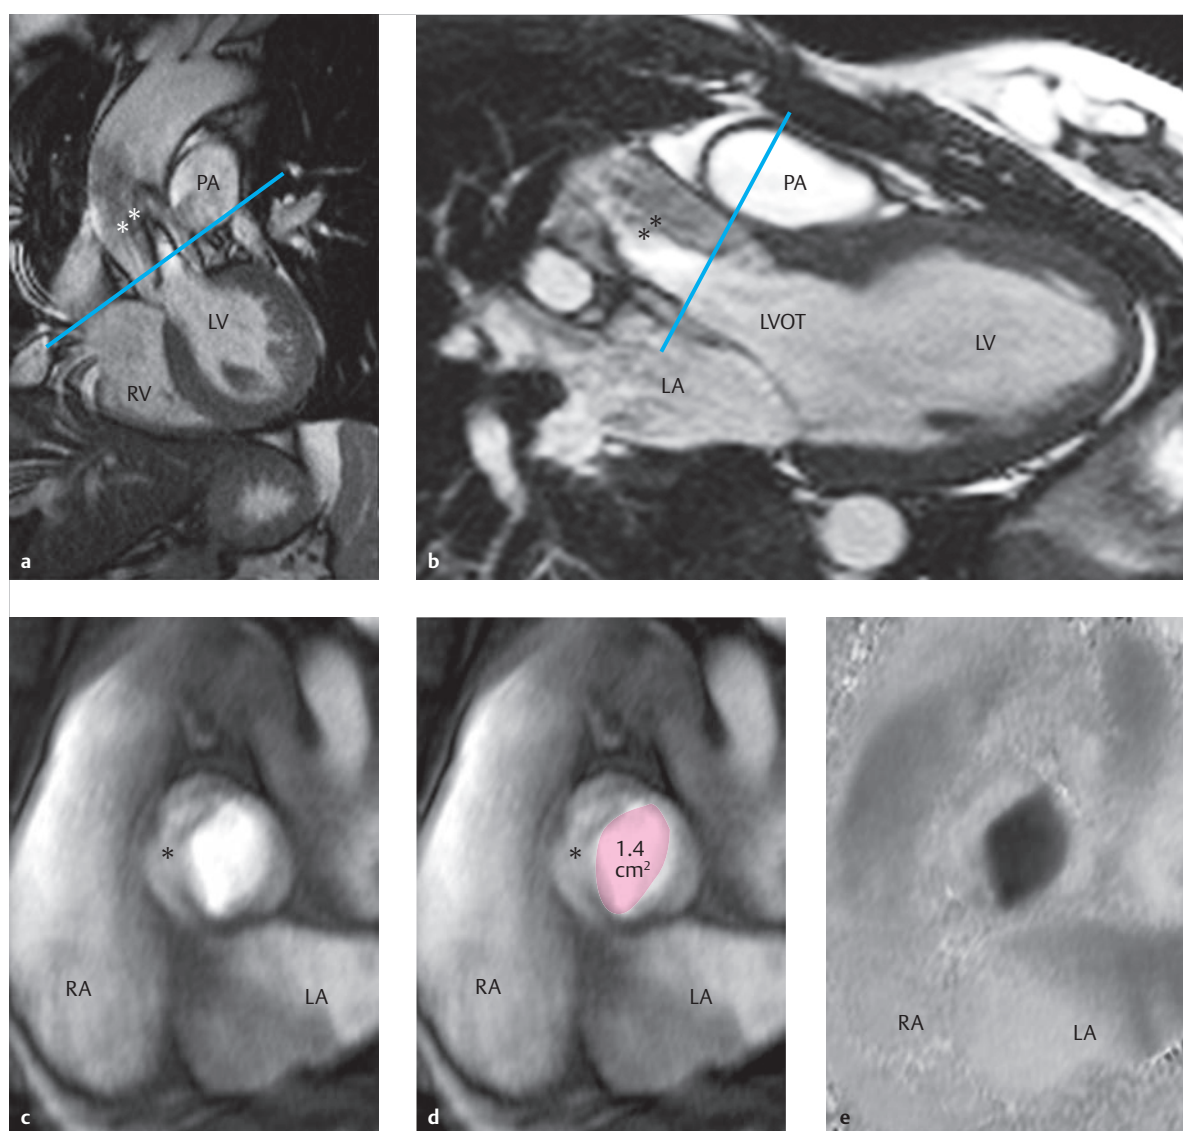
Isolated, congenital “bicuspidalized” type 1 N/R aortic valve and moderate stenosis. (► Fig. 4.58). Twenty-five-year-old male patient. A maximum instantaneous pressure gradient of 30 mmHg was estimated using doppler echocardiography. The patient exhibited no clinical symptoms.
